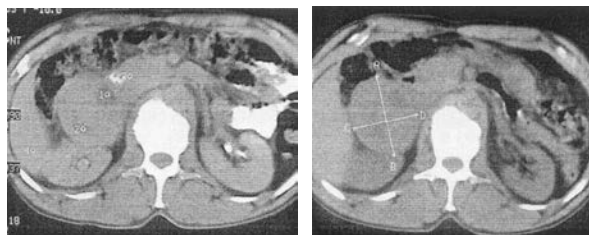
CT Scan of abdomen showing Rt adrenal mass
